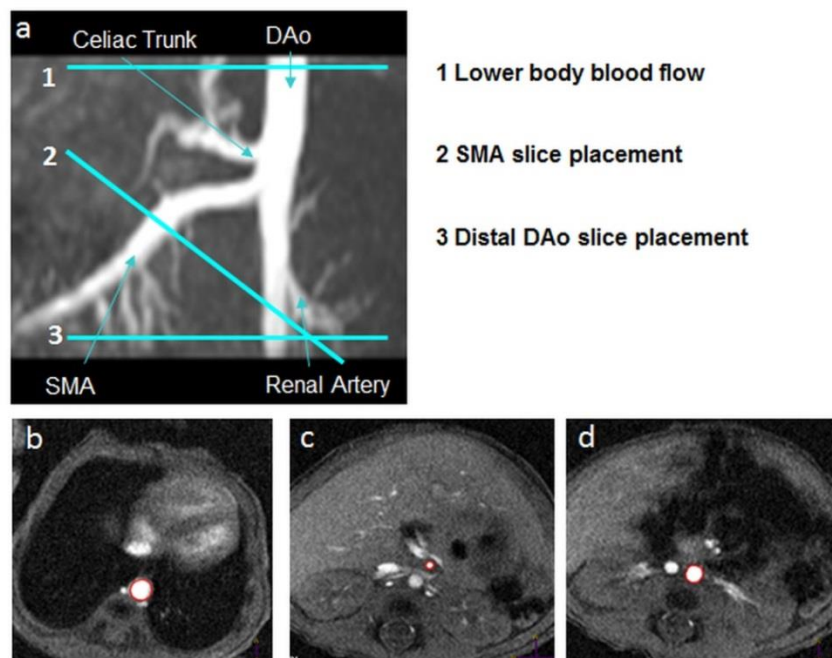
Study design: PC MRI sequence to quantify Lower blood flow, Intestinal blood flow and distal DAo flow volume. Angiography of the abdominal arteries in a 1.5kg infant: shows slice location of all three sequences.
